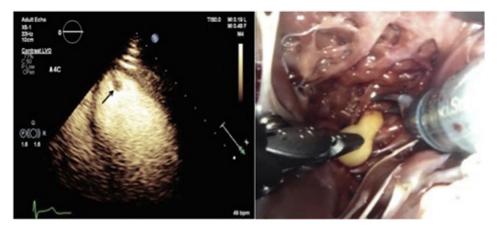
(Left) Apical 4-chamber view transthoracic echocardiogram with definity contrast showing a pedunculated left ventricular apical mass. (Right) Intraoperative image showing an intracardiac lipomatous mass at the apex of the left ventricle.
